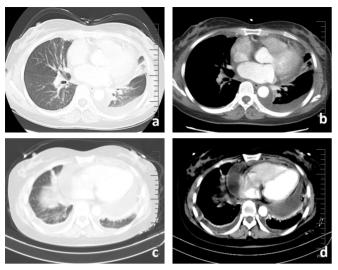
Contrast-enhanced computed tomography (CT) of the thorax on initial admission (a, b). ACT scan of her thorax 3 years later (c, d).
